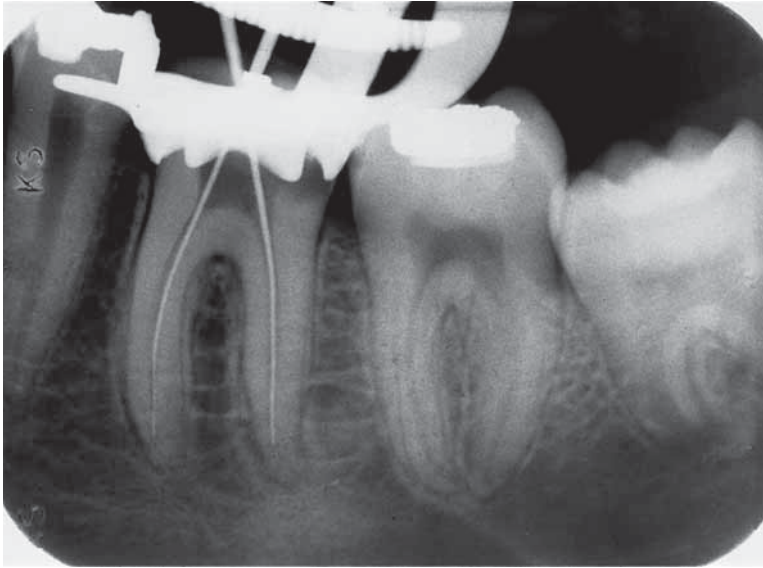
Endodontic files seen on a radiograph. Radiograph of a lower left first molar where endodontic files have been placed within the root canals approaching the cementodentinal junction apically.
